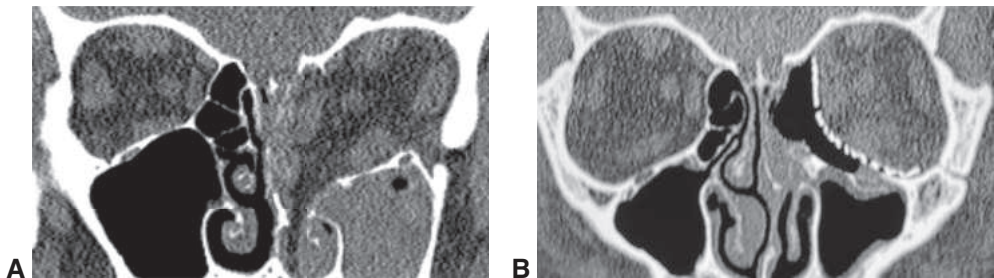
Large orbital floor and medial wall fracture with herniation of tissues before and after surgery. A, Coronal CT image of extensive left floor and medial wall fracture with profound prolapse of orbital soft tissues. B, Postoperative coronal CT image of left orbital floor and medial wall fracture repaired with molded titanium implant to recreate the medial wall and floor. (Courtesy of Steven M. Couch, MD.)
